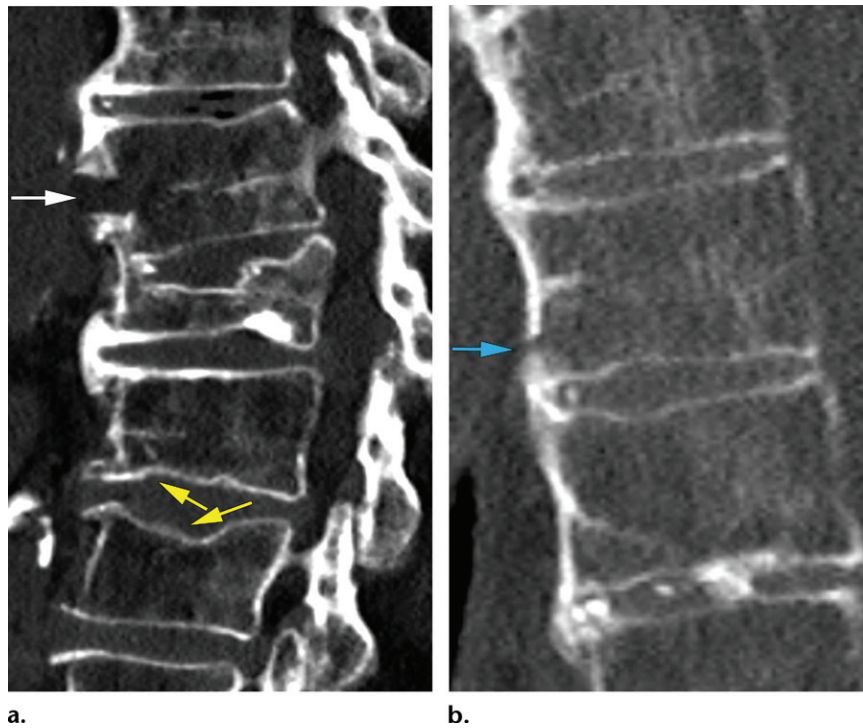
Noncontiguous fractures in a 91-year-old woman with DISH who fell from her walker and presented with acute on chronic back pain. (a) Sagittal CT image shows a transverse distraction fracture (white arrow) of the L1 vertebra. Mild L3 and L4 compression injuries (yellow arrows), subacute to chronic in appearance, and a severe L2 compression deformity were unchanged from a prior imaging study. CT of the whole spine was performed after these fractures were diagnosed. (b) Sagittal CT image through the midthoracic spine shows an additional anterior transverse fracture (arrow) of T8.
